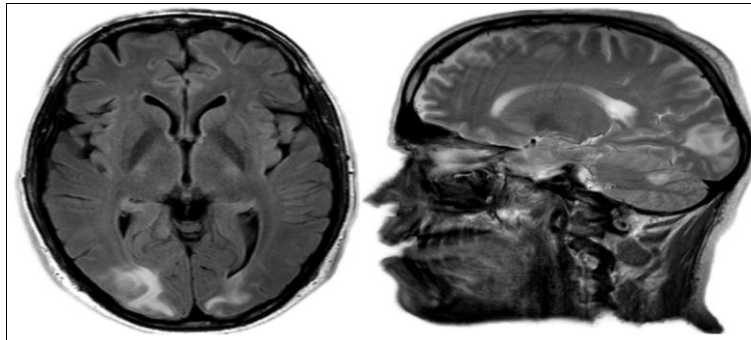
Axial FLAIR MRI sequence and Sagittal T2 MRI sequence showing PRES.
